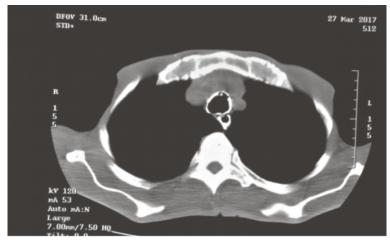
Chest CT scan in mediastinal window showing contrast material in the trachea and esophagus.
